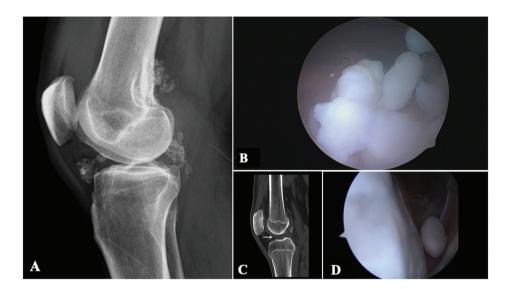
(a) Lateral knee radiograph of a 37-year-old male patient showing multiple well-defined, rounded opacities of similar size confined to the right knee joint space. No bony erosions were present. Concentric calcifications in the form of rings, arcs, and swirls were observed. (b) Arthroscopic view of a case with synovial chondromatosis. (c, d) Arthroscopic and radiological views of the same nodule. The degenerative change of the joint surface is shown in c (white arrow)
